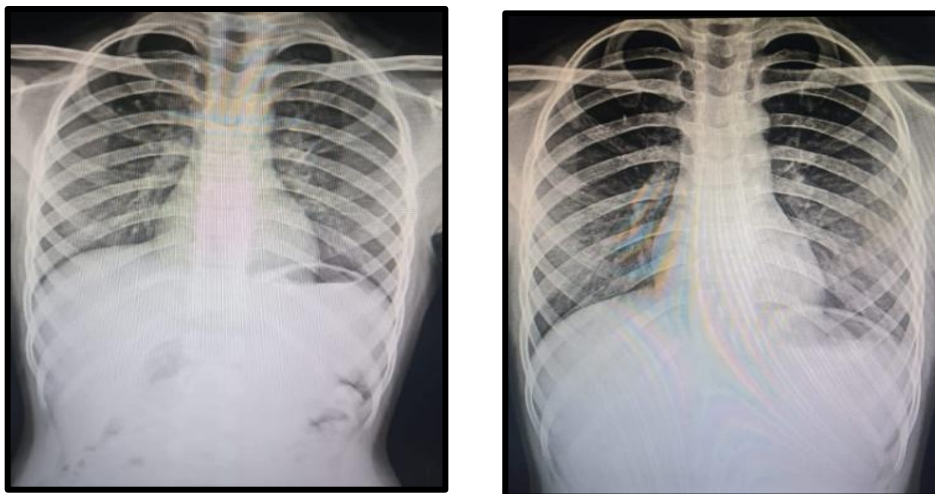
Showing X-ray – PA View before treatment and after treatment
